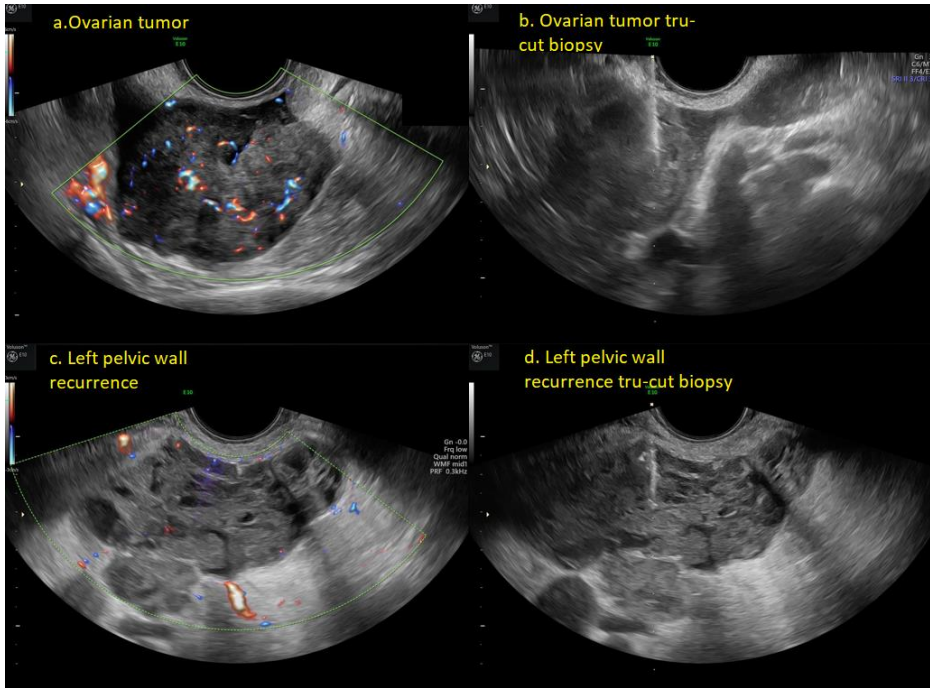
Ultrasound-guided biopsy: a) Ovarian tumor, b) Transvaginal ultrasound-guided tru-cut biopsy, c) Left pelvic wall recurrent ovarian cancer, d) Transabdominal ultrasound-guided tru-cut biopsy. © Karina Liuba picture database, with patient's consent.
